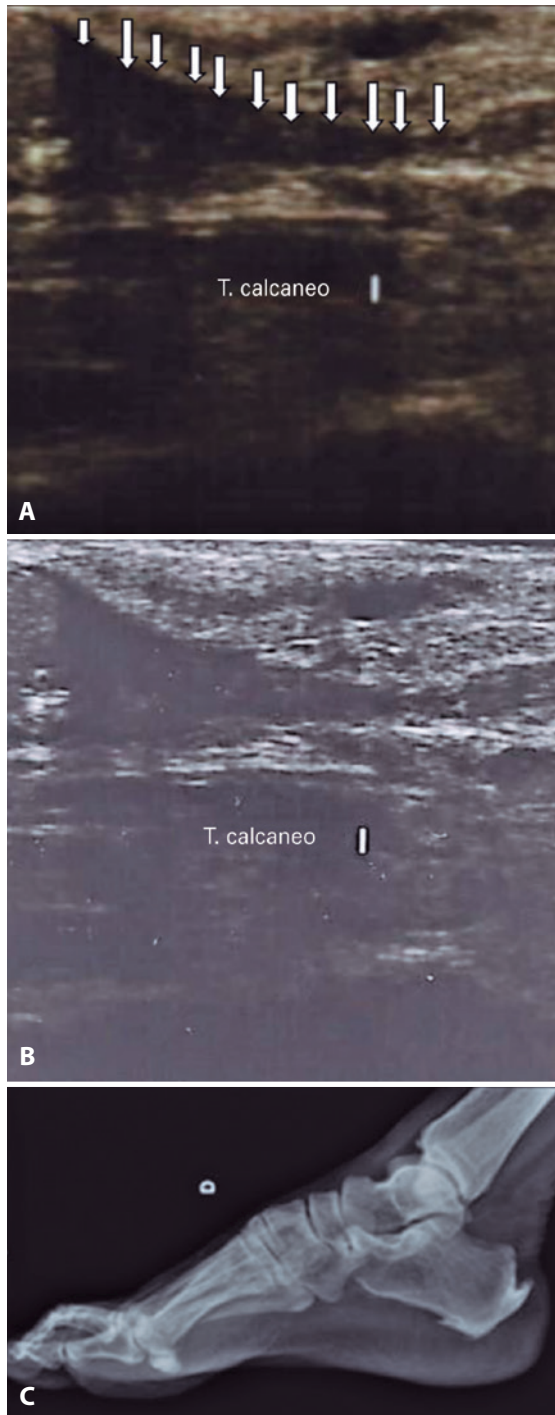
A. Diagnostic ultrasound images showing rupture of the calcaneal tendon. B. Pre-operative X-ray showing the dorsal calcaneal spur.
